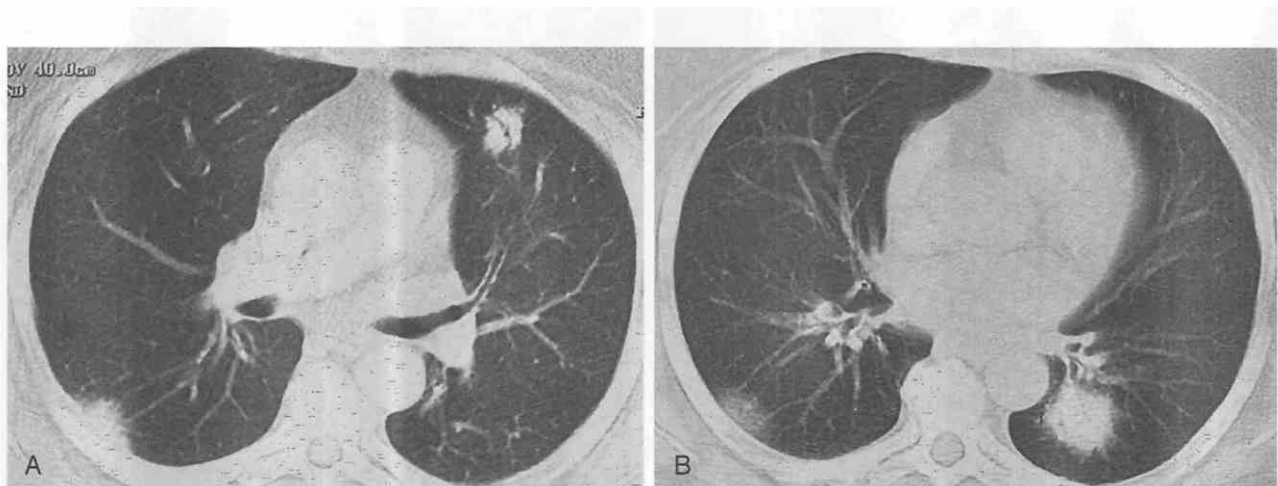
Primary pulmonary lymphoma manifesting as bilateral pulmonary opacities. *A* and *B*, CT shows focal, poorly margined nodular opacities in both lungs. Air-bronchograms within opacities are suggestive of the diagnosis.
